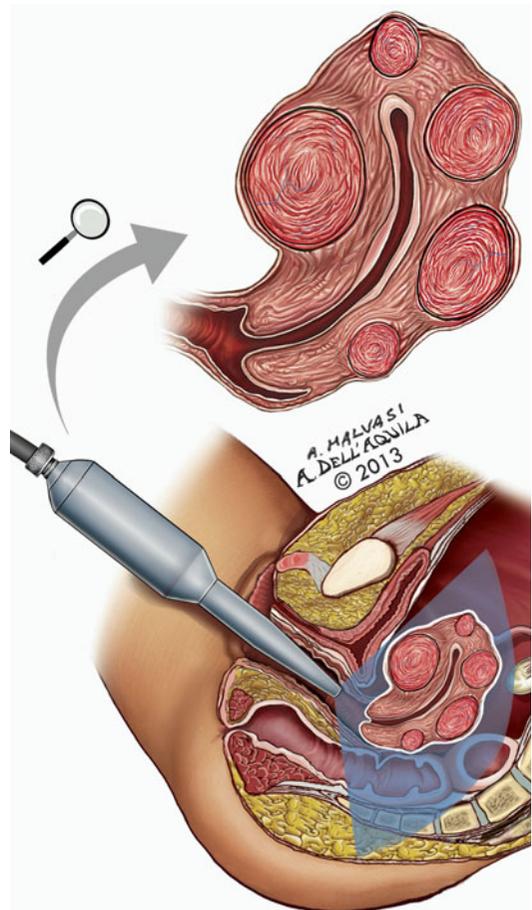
A transvaginal ultrasonography showing a myomatous uterus
